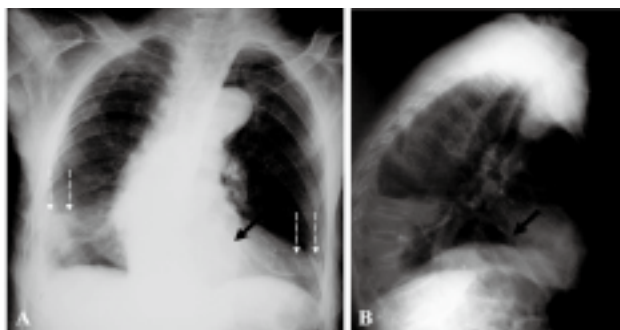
Posteroanterior (A) and lateral (B) chest radiographs show the hiatal hernia, reveal mild congested lung fields with Kerley B lines (dashed arrows) compatible with pulmonary oedema. There was also an fluid–air level behind the heart (arrows).
